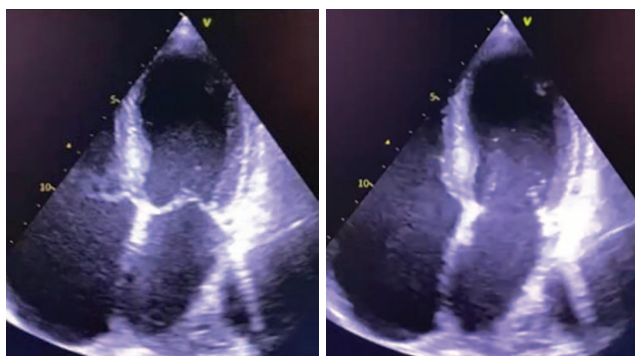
Echocardiography from 17.01: diffuse myocardial hypokinesia, no local contractility disorders detected
